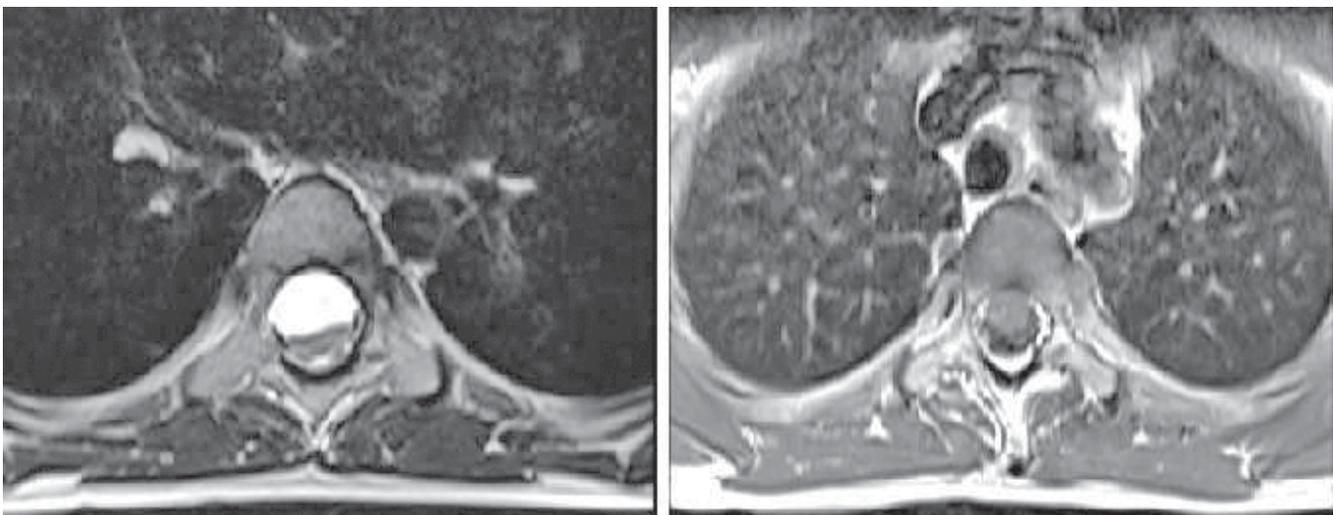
MRI showing transverse section of the cervico-dorsal spine with the Neurenteric cysts at T5-8 level, T1 (cysts are isointense) and T2 (cysts are hyperintense) weighted images.
